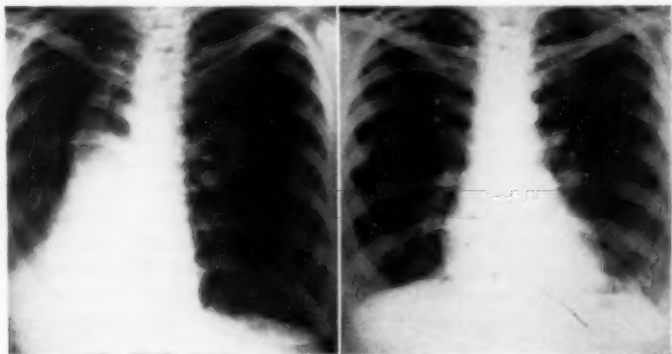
To left, roentgenogram showing atelectasis of right middle and lower lobes, with displacement of heart to the right, due to obstruction by bronchial adenoma in a young woman (V. A., 39 years old, Case 2). To the right, roentgenogram taken after endoscopic removal of the tumor, showing normal re-aeration.
